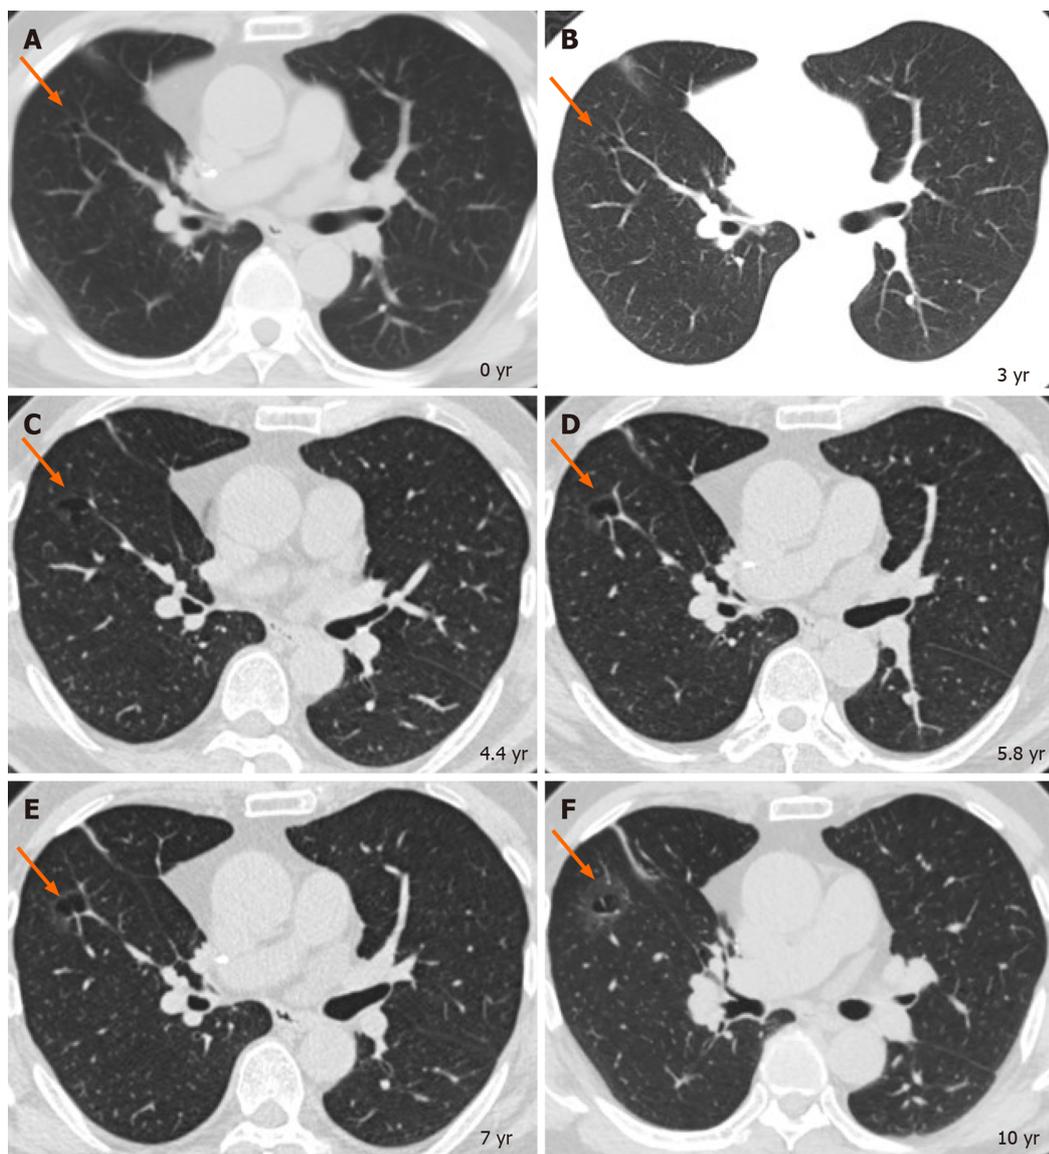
Serial computed tomography images over 10 years in this patientshowed the gradual evolution of an 11-mm right lower lobe thin-walled cystic airspace (A, arrow) into a 31-mm cystic airspace with a thick wall demonstrating as a GGO (F, arrow). A: Before the first operation (2007); B: Three years later; C: 4.4 years later; D: 5.8 years later; E: 7 years later; F: 10 years later.
